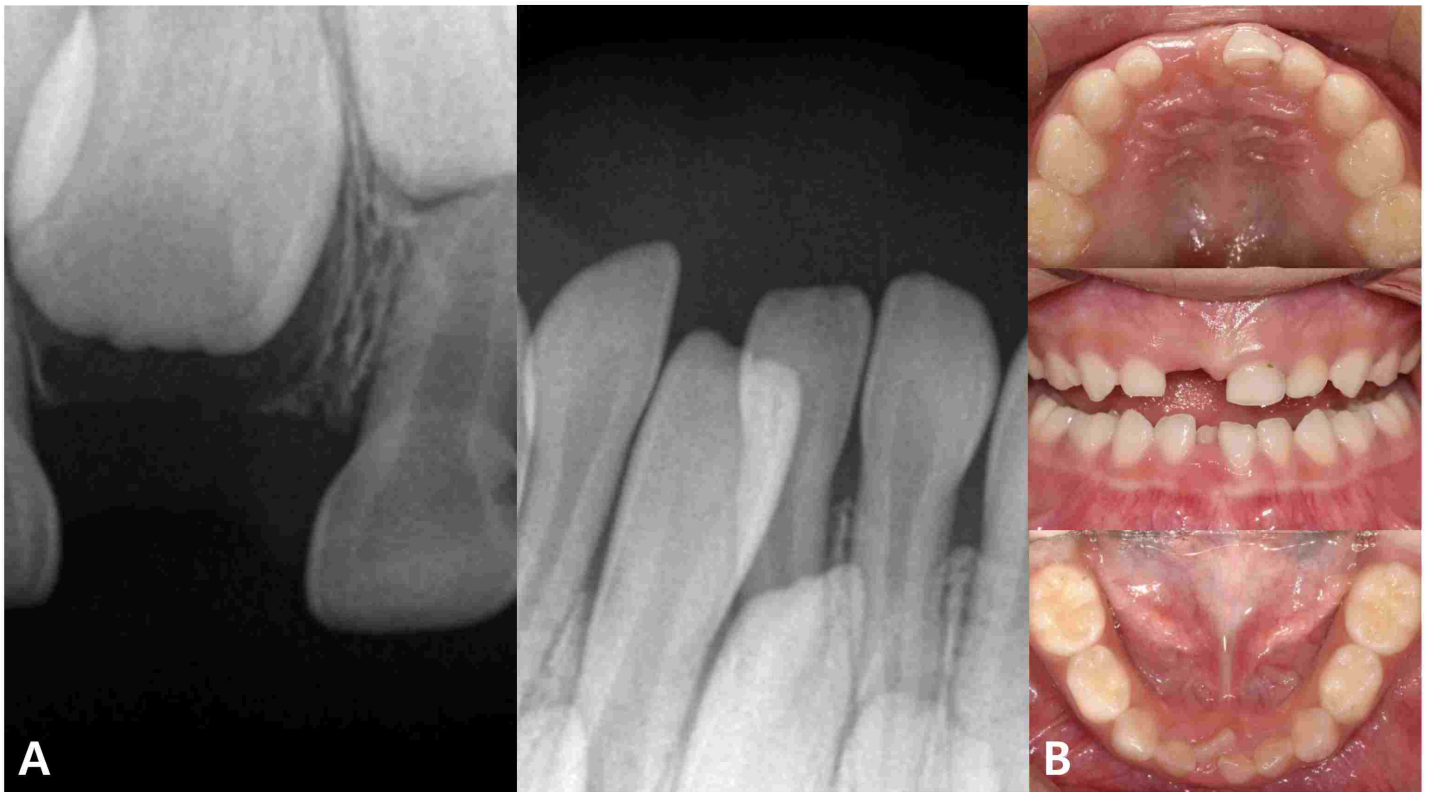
Six months after tooth extractions. (A) Periapical radiograph of teeth #11 and #41. (B) Intraoral photo.
